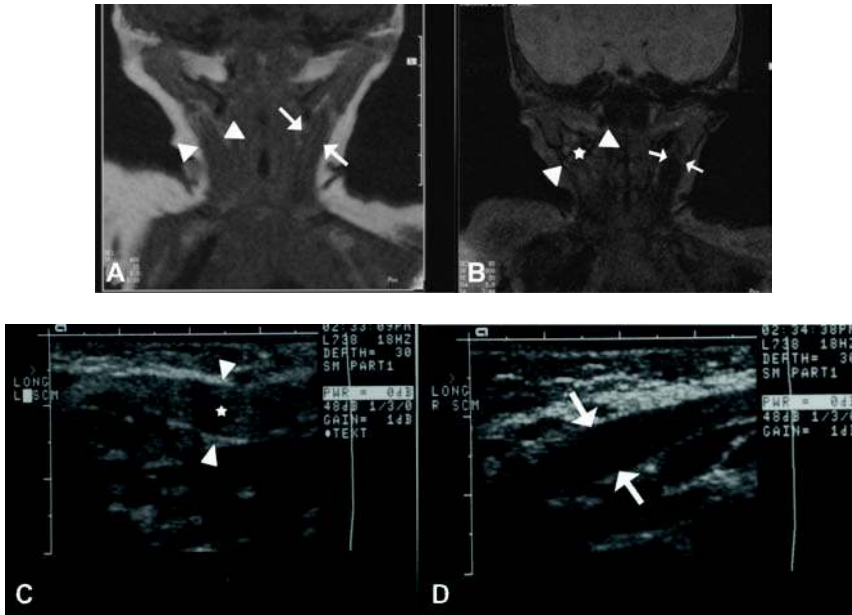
Ultrasonography (A) show diffuse enlargement of the right sternocleidomastoid muscle (between arrowheads), T2-weighting (B), and Coronal MR images with T1-weighting (C,D). There is mildly high signal on T2-weighted MR (* in B) and increased echogenicity on sonography (* in C) compared with the normal-left sternocleidomastoid muscle (between arrows in D).
